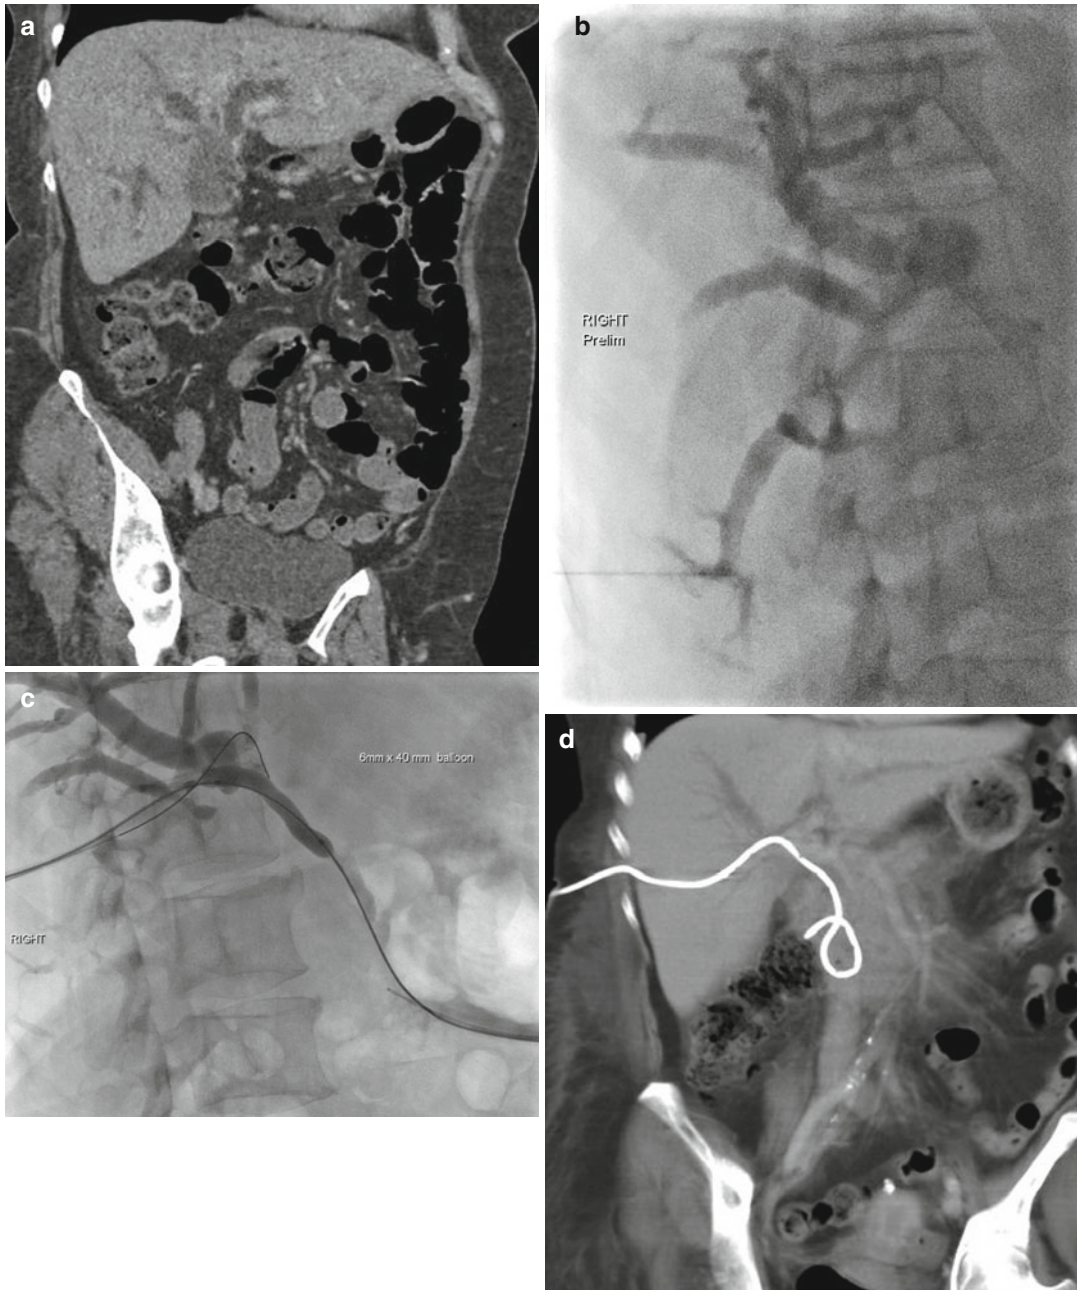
(a–d) Biliary drain. (a) Coronal portal venous phase CT abdomen demonstrating marked intrahepatic biliary dilatation due to gallbladder carcinoma infiltrating ducts at the hilum. (b) Percutaneous cholangiogram with contrast identifying dilated intrahepatic ducts, but no drainage into the common bile duct (CBD). (c) Balloon
